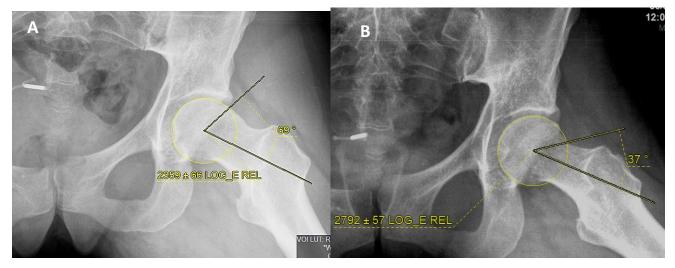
Plain X-ray Dunn view of both hips of a patient showing; A. preoperative alpha angle 69°, and B. postoperative alpha angle 37°
